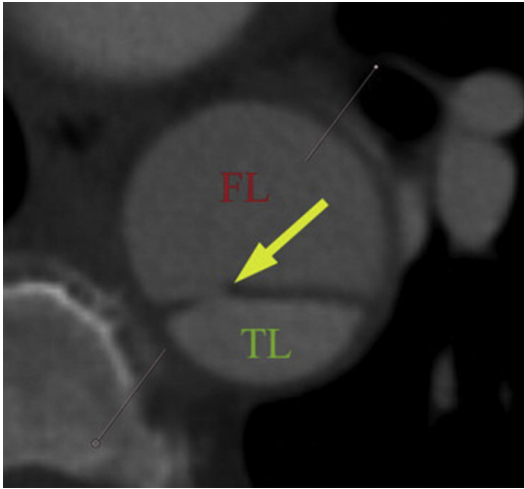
Aortic dissection with an entry tear (*arrow*) in an intimal flap separating the TL from the FL, as seen on axial view of CTA. (From Tolenaar JL, van Keulen JW, Trimarchi S, et al. Number of entry tears is associated with aortic growth in type B dissections. *Ann Thorac Surg* 2013;96(1):40; with permission.)
